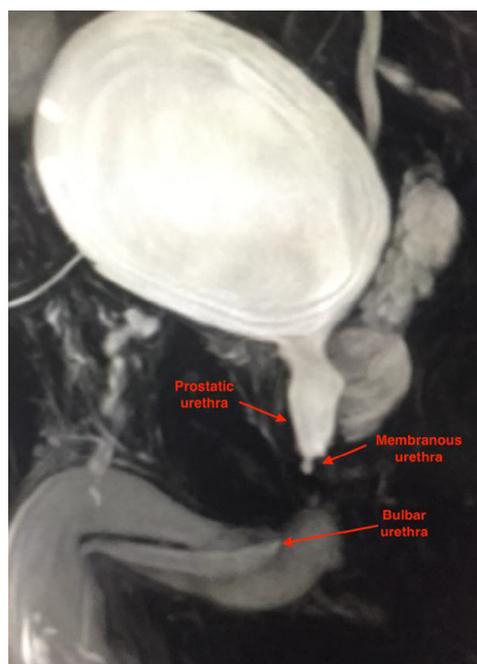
T2-weighted magnetic resonance image of the pelvis with pelvic fracture urethral injuries using our protocol for image acquisition.
